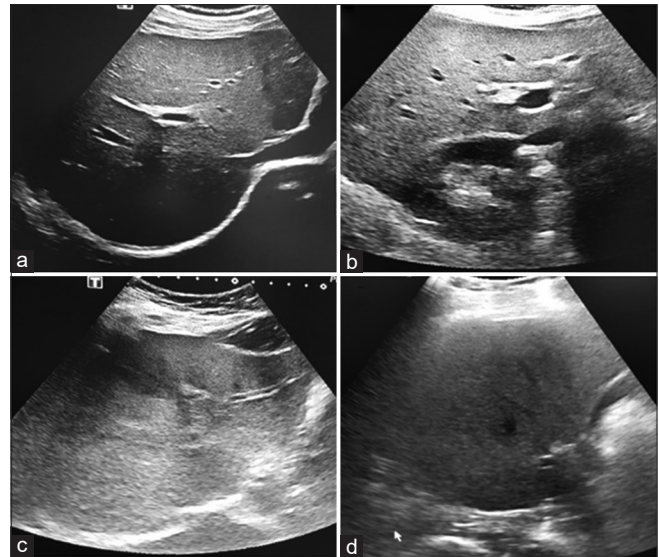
Ultrasonography in patients with different liver steatosis grades: (a) Grade 0, (b) Grade 1, (c) Grade 2, (d) Grade 3
